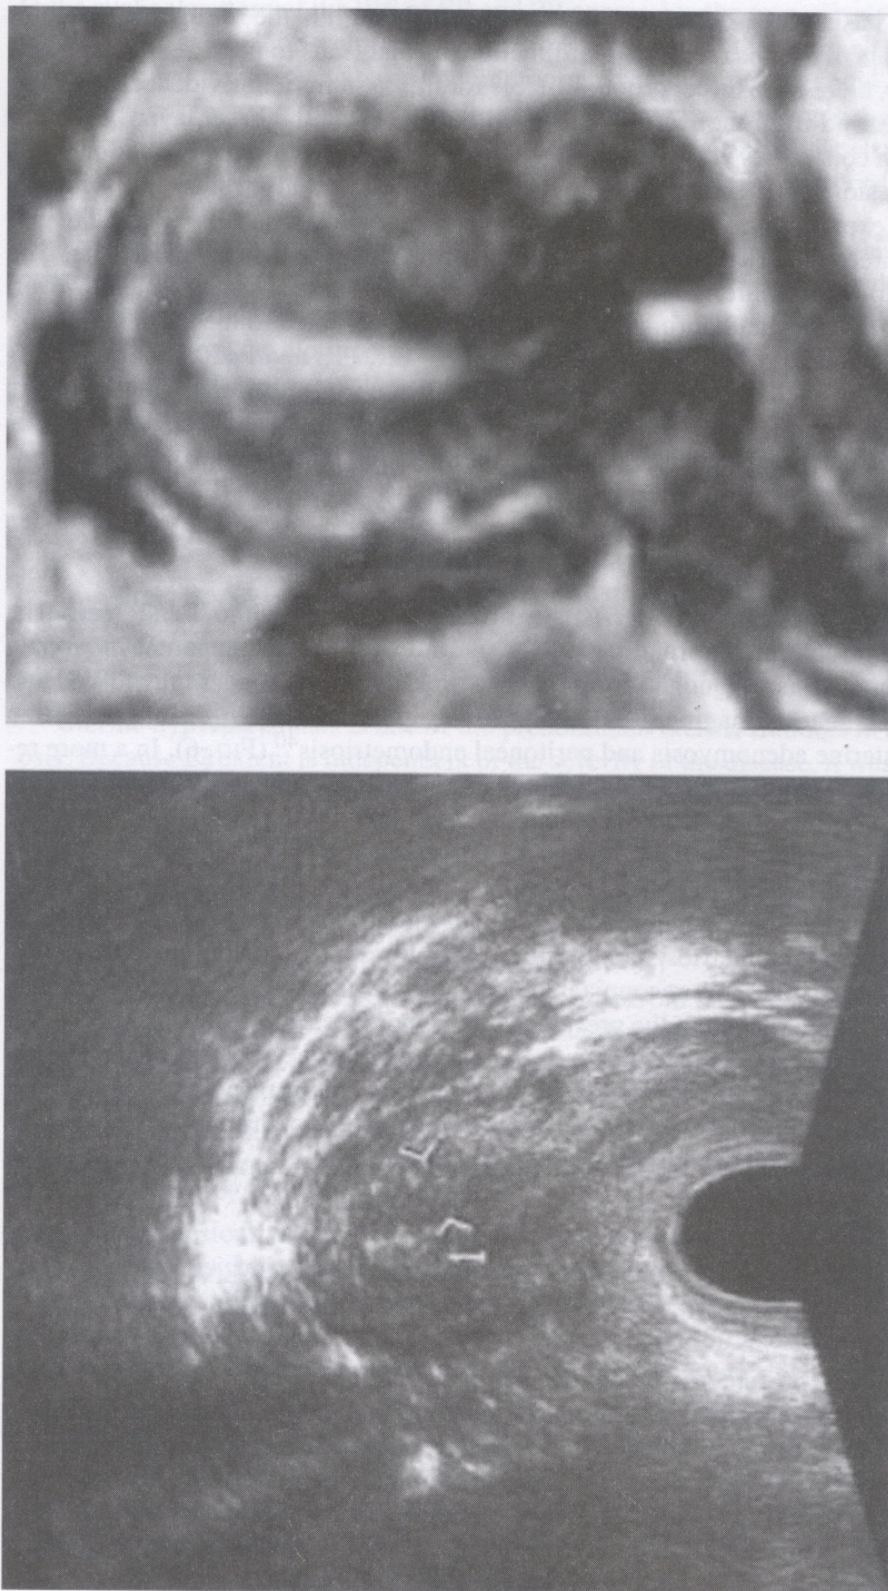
Transvaginal sonography (TVS) and magnetic resonance imaging (MRI) of the uterus of a 32-year-old woman with moderate endometriosis. In TVS, the "halo" is broadened in the posterior wall of the uterus. In MRI, the junctional zone is broadened in both the anterior and posterior wall of the uterus with the typical "patchy" appearance.
